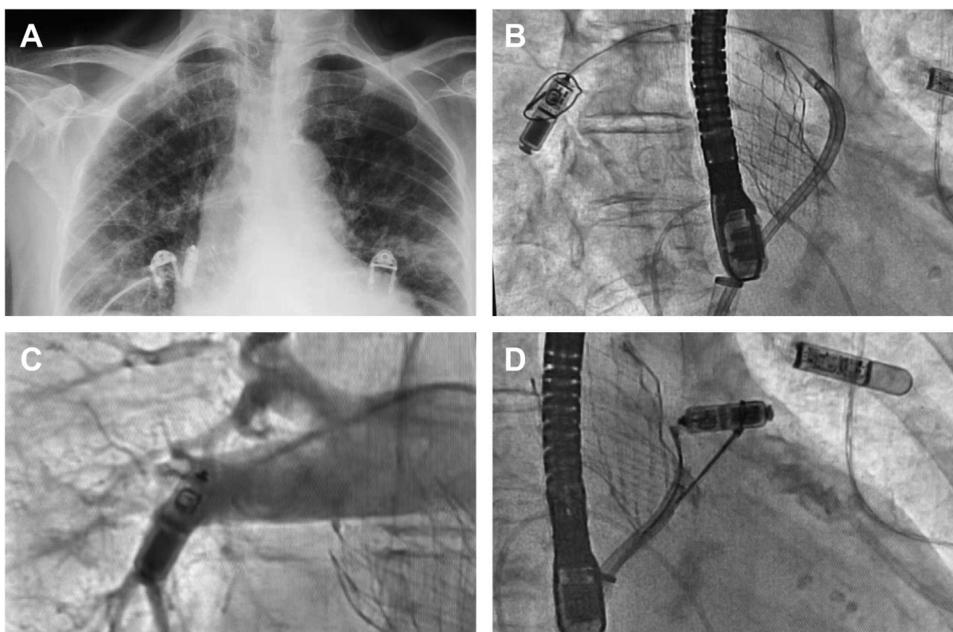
A: Embolized Micra on chest radiograph. B: Pulmonary angiography confirmed a right lower segmental pulmonary artery partial occlusion. C: A 20-mm, single-loop snare over the Micra device. D: Second snare securing the device within the pulmonary artery.
